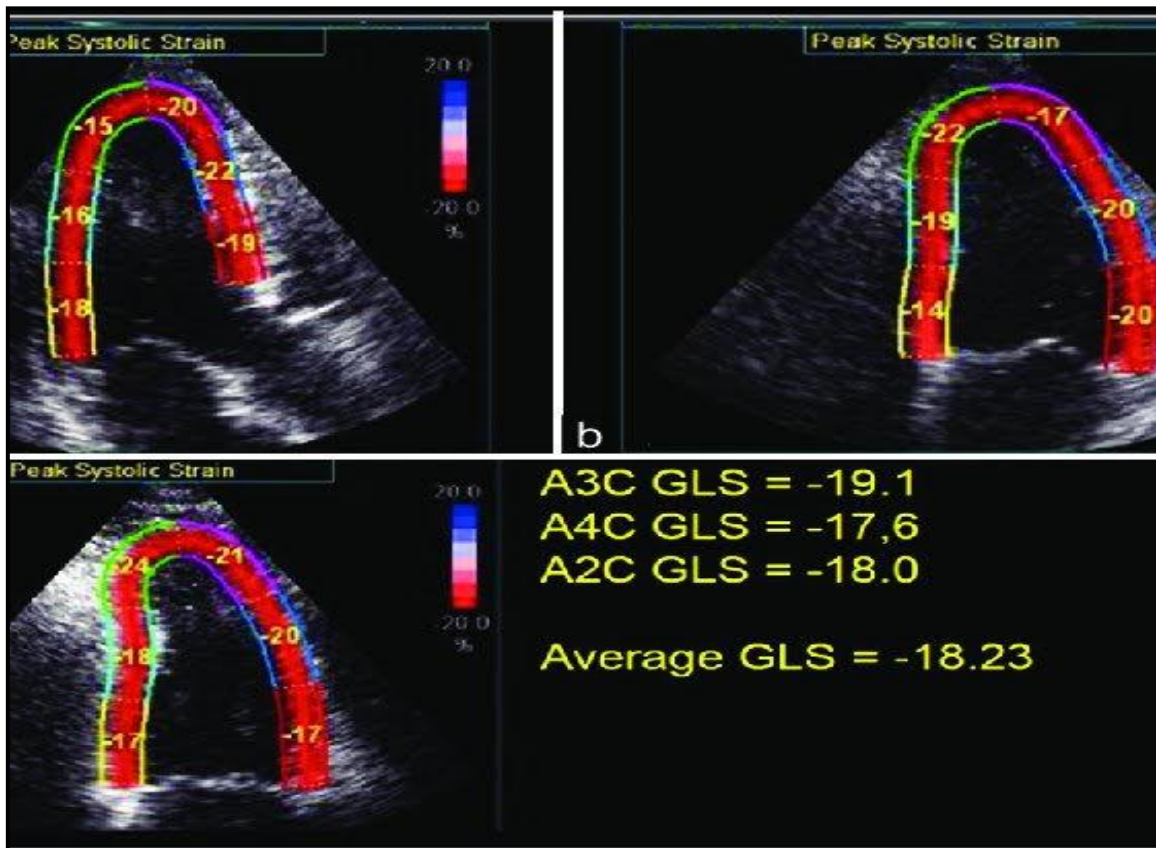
Speckle Tracking Echocardiography Images
